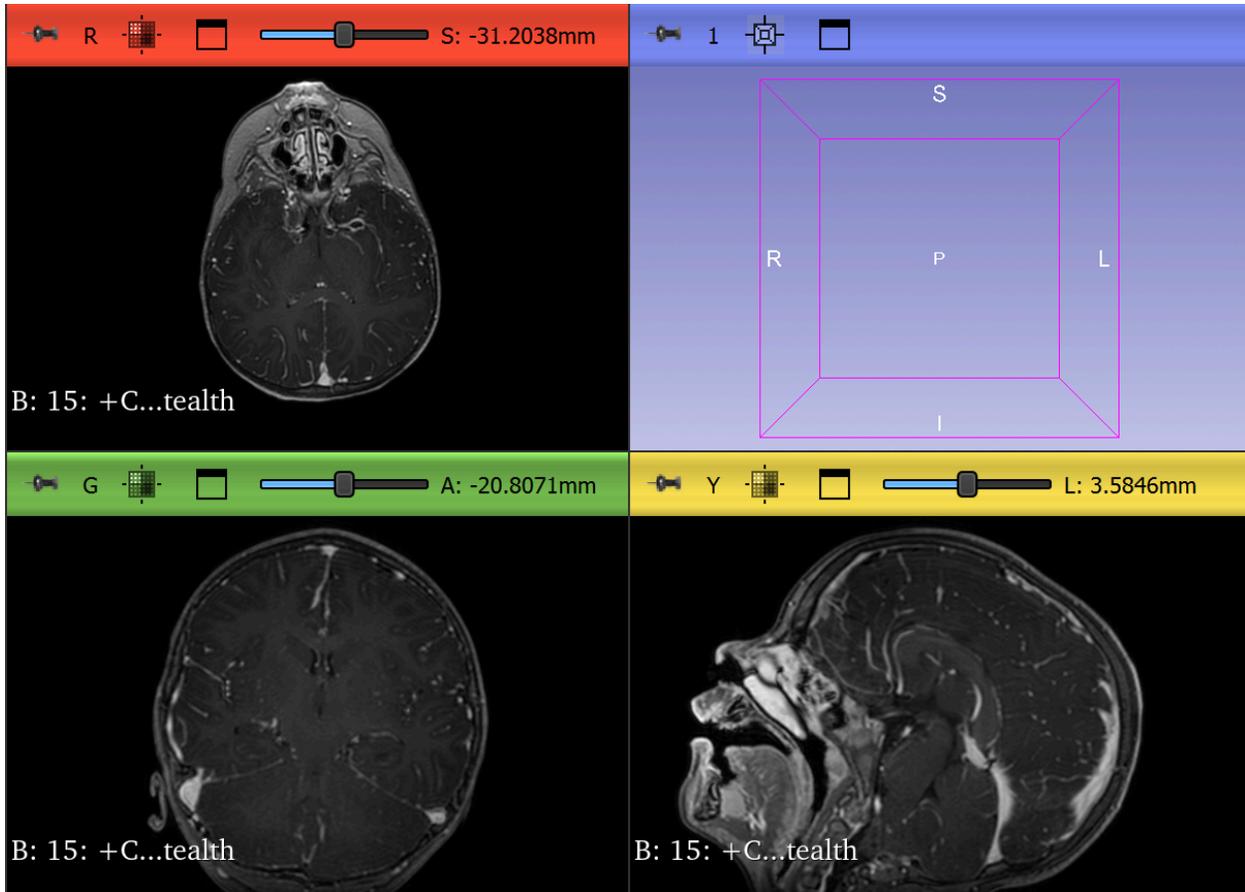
5-7 year old patient DICOM data in 3D Slicer prior to segmenting T1-weighted MR images and exporting into SimNIBS.
